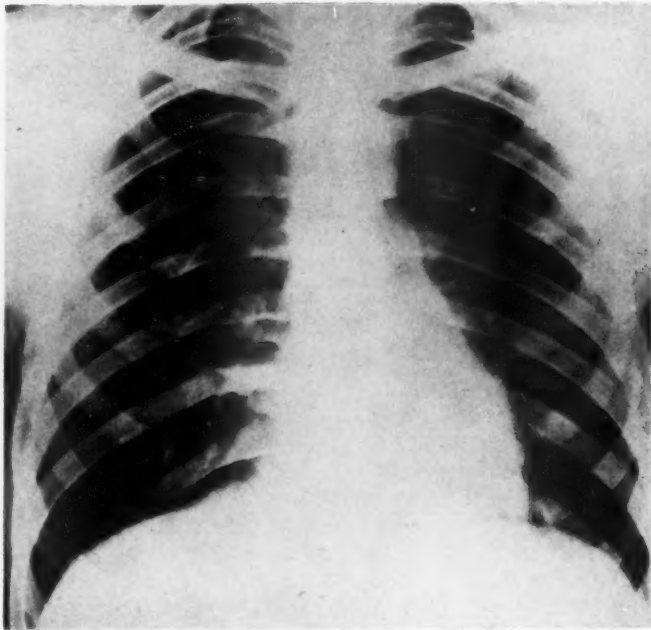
Case 2: The cyst now empty. Roentgenogram taken in 1937, when the patient was 17 years old.
